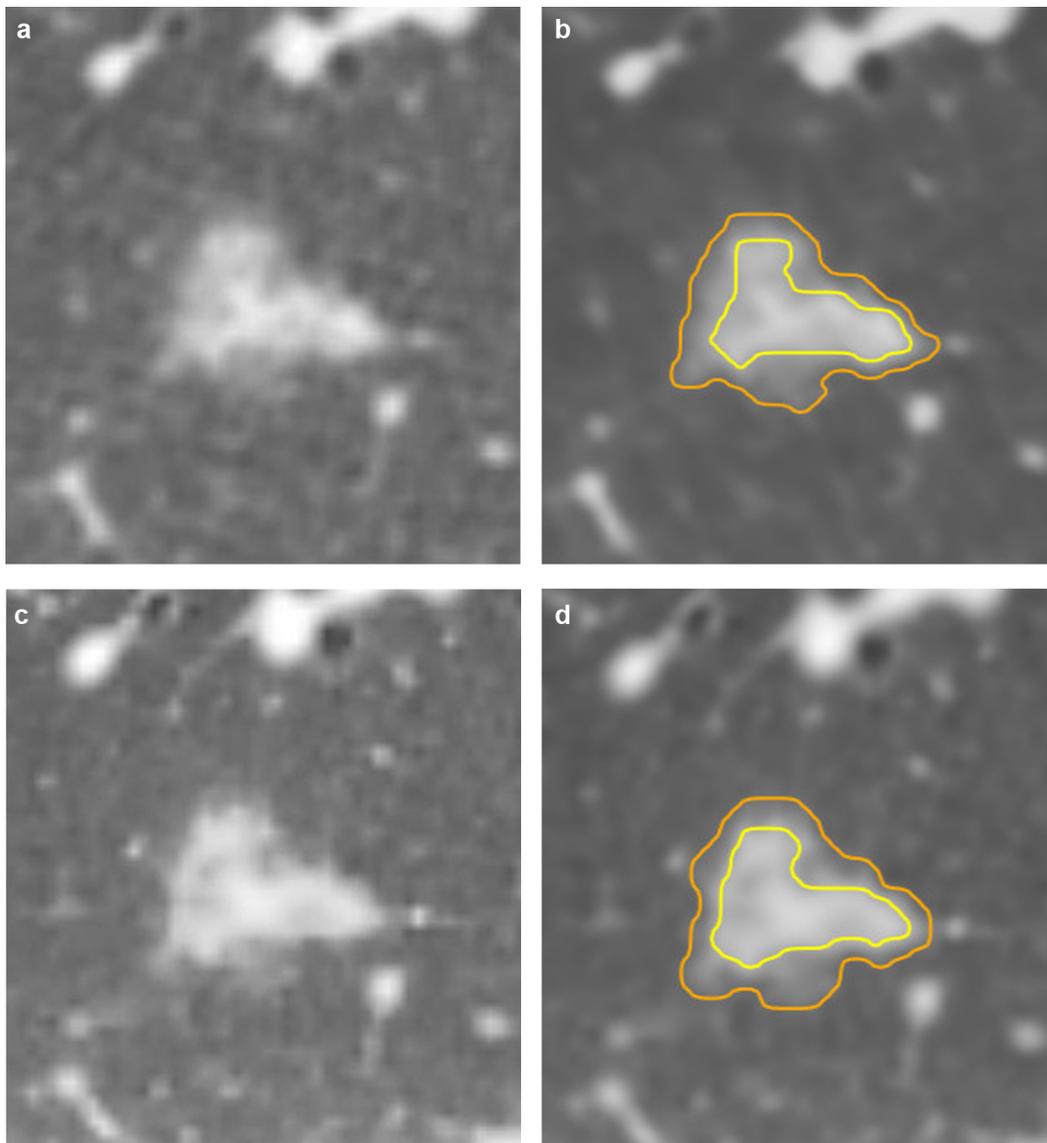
Unenhanced (A and B) and enhanced (C and D) CT scans displayed with lung window (window width, 1500HU; level, -700HU) show a subsolid nodule in a 63 year-old female patient which was confirmed as minimally invasive adenocarcinoma. Orange boundaries on B and D indicate borders of the whole nodule, while yellow boundaries indicate borders of the solid component. The largest diameter, volume, mass, and attenuation of the whole nodule was greater on enhanced CT scan (13.1 mm, 1164 mm³, 633 mg, 456HU) than on unenhanced CT scan (12.5 mm, 1026 mm³, 552 mg, 462HU).
